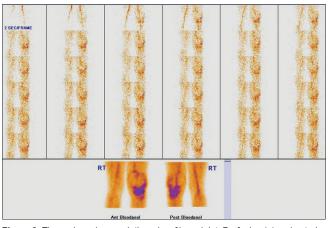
Three phase bone scintigraphy of knee joint. Perfusion (a) and anterior and posterior blood pool (b) images demonstrates increased perfusion and blood pool concentration in left knee joint consistent with synovitis
